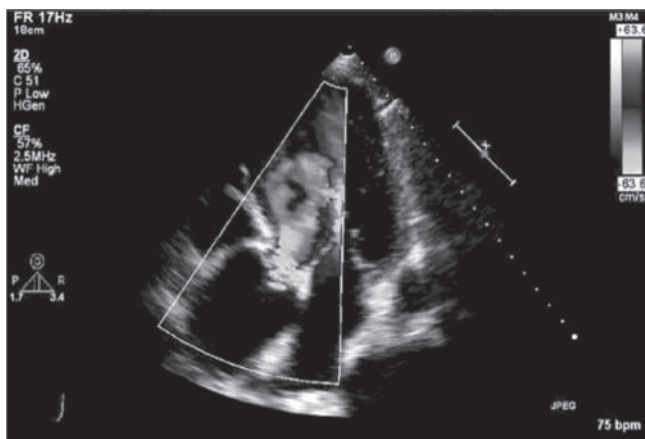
Dilated aortic root with severe aortic regurgitation from apical five chamber view.
